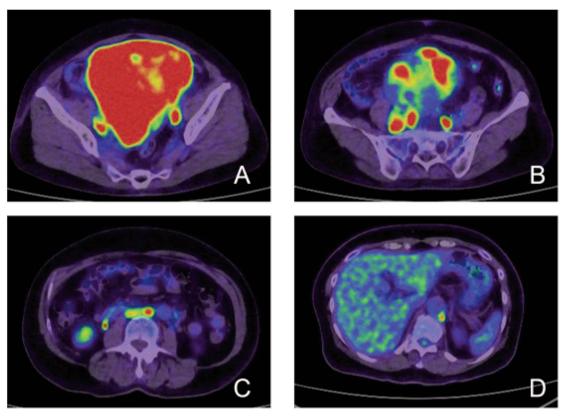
Whole-body positron emission tomography/computed tomography showing high ¹⁸F-fluorodeoxyglucose accumulation within the uterine tumor (A, SUVmax 16.0), pelvic lymph nodes (B), para-aortic lymph nodes (C), and diaphragmatic lymph nodes (D).
